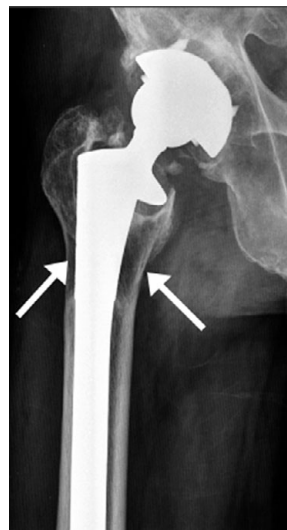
Anteroposterior (AP) radiograph right hip demonstrating stress shielding
